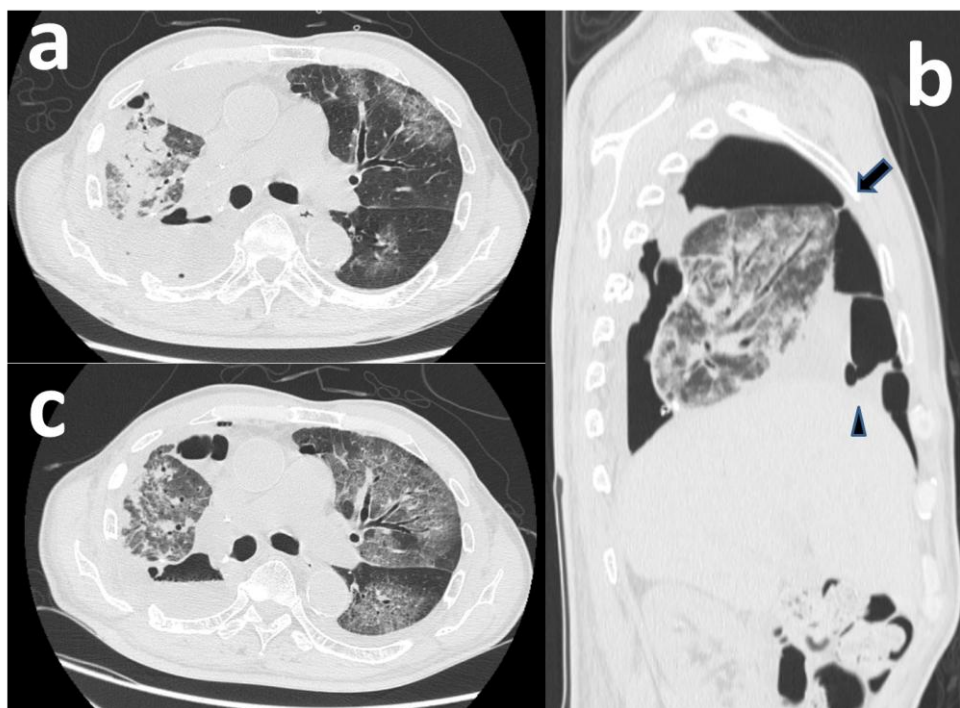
On postoperative day 8, CT imaging demonstrated bacterial pneumonia in the right middle lobe and diffuse ground-glass opacities in the left lung (a). The middle lobe had been fixed to the diaphragm at the point indicated by the arrow and the arrow head (b), however, sutures were removed and the middle lobe was rotated approximately 90°. On postoperative day 40, left lung consolidation had worsened, as seen on CT imaging (c).
